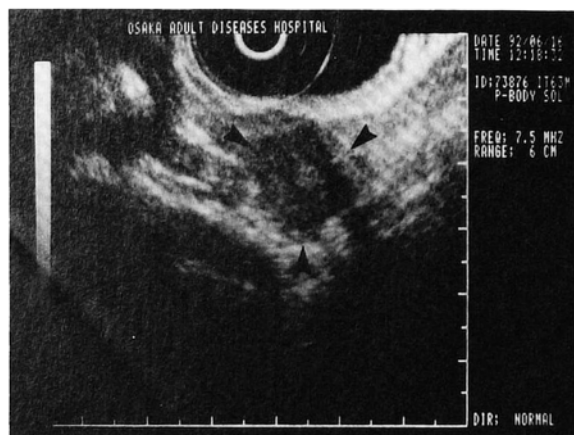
An endoscopic sonogram of a patient with pancreatic cancer. An indistinctly defined pancreatic mass of 2 cm in diameter with relatively irregular internal echoes was found between the body and tail of the pancreas.
